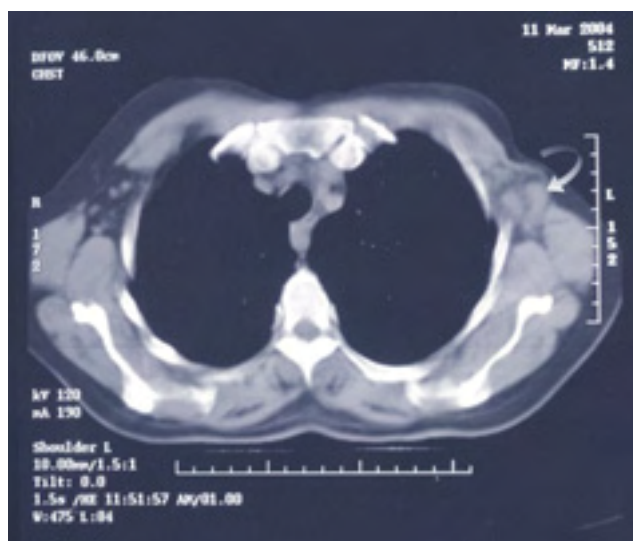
CT of the thorax during the second relapse. A mass of soft tissue density is 'filling up' the left axillary cavity (curved arrow)
